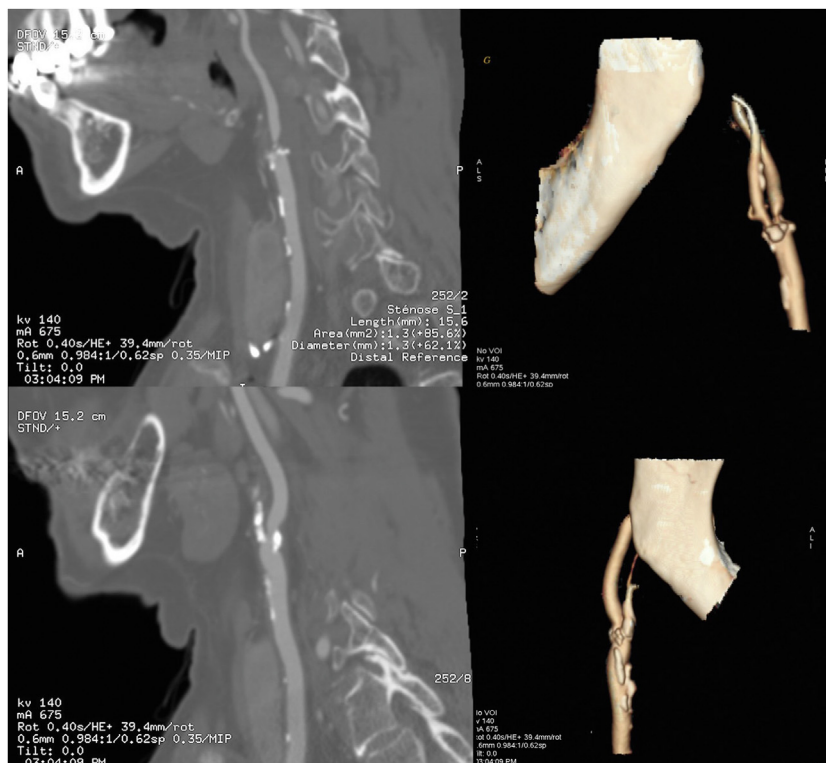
Computed tomography angiogram showing significant stenosis in the left internal carotid artery (ICA; Upper Row) and right ICA (Lower Row).
